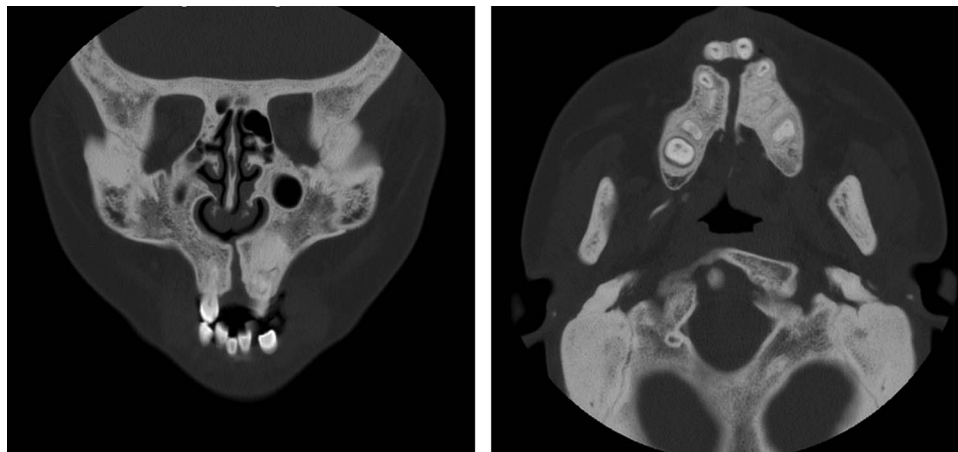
Pretreatment computed tomography.
